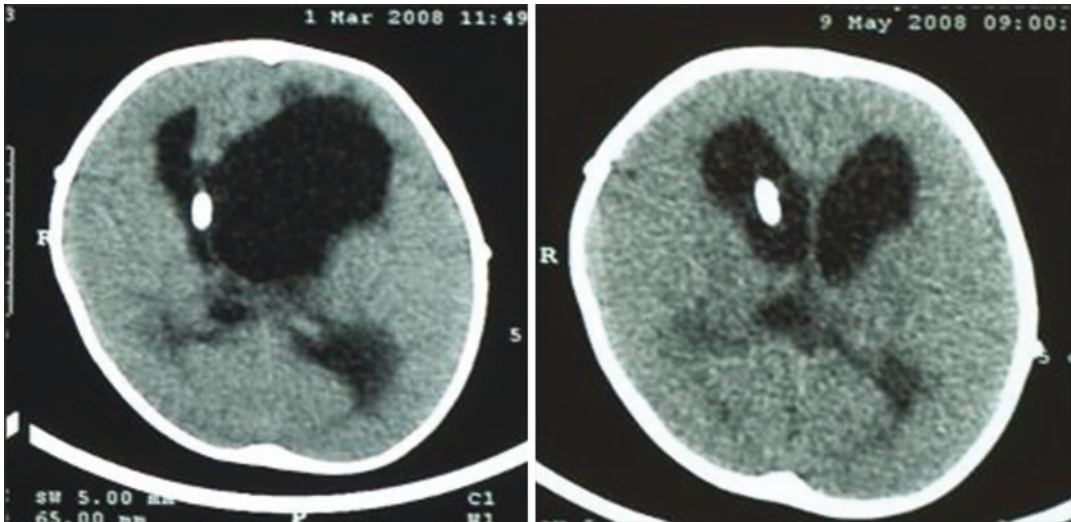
Preoperative and postoperative CT of multiloculated HCP. Lateral ventricle endoscopic fenestration induced an evident reduction of HCP. The post-op CT shows symmetric frontal horns and reduction of occipital horns
